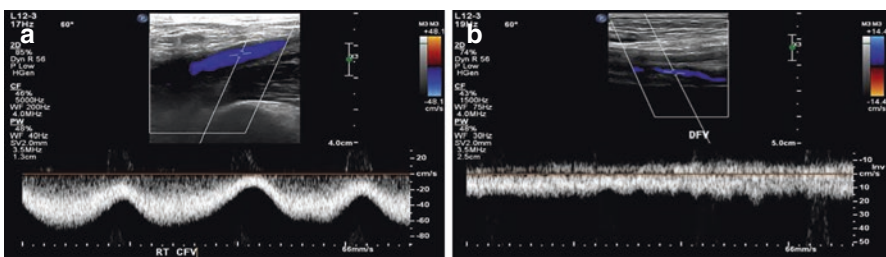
Note the normal, respire-phasic waveforms with the gentle undulation with expiration and inspiration in (a). With proximal obstruction, the ability for changes in intra-abdominal pressure to influence the flow is obliterated, resulting in a non-phasic, flattened, or continuous Doppler venous waveform (b). (a) Normal phasic waveform in the common femoral vein that varies with respiration during the cardiac cycle. (b) Abnormal waveform in the common femoral vein. The absence of phasicity indicates an ilio caval venous obstruction. (Images courtesy of J. Chung)
